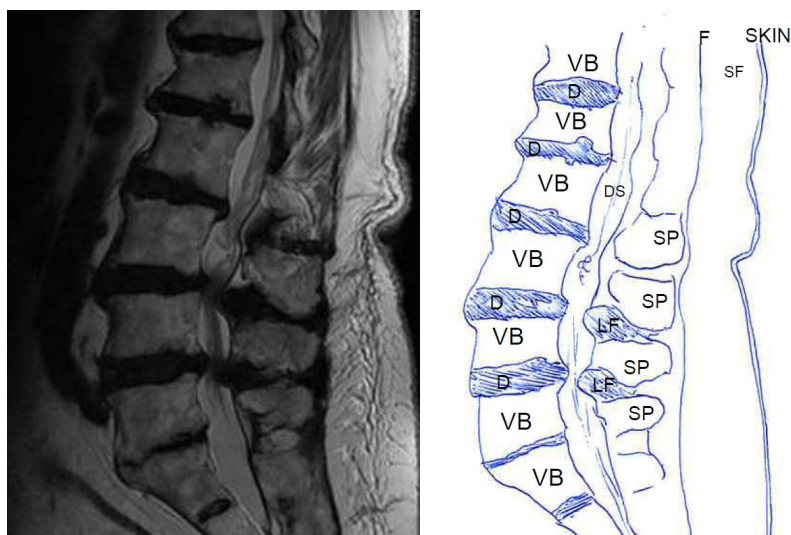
Saggital MRI of a lumbar spine with LSS in some segments. (All MRI images are used with the allowance from the radiologic department at Akershus University Hospital). VB = Vertebral body, D = Intervertebral disc, DS = Dural sac, SP = Spinous process, LF = Ligamentum flavum, F = Fascia, SF= Subcutaneous fat, FJ = Facet joint, PM = Psoas muscle, ESM = Erector spinae muscle.
